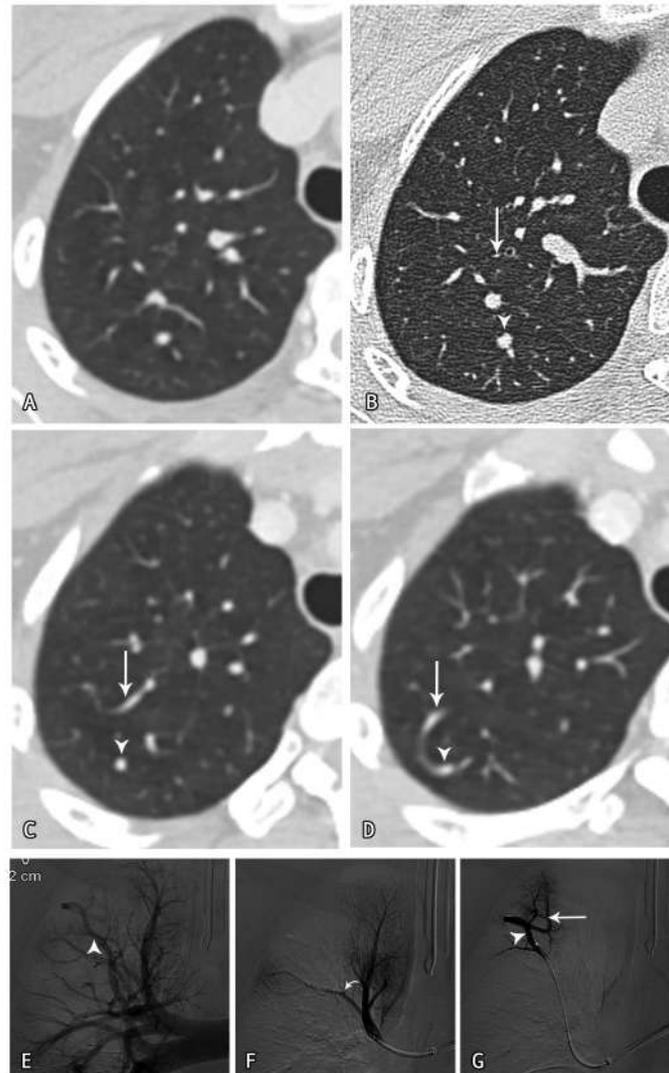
Pulmonary artery-to-pulmonary artery anastomosis in the right upper lobe. CT in lung window (A) and HRCT (B) at a similar level of the right upper lobe showing size disparity in the subsegmental pulmonary arteries in the right upper lobe. The thrombosed artery (arrow) is smaller than the accompanying bronchus while the patent one is dilated (arrowhead). More peripheral (C, D) the distal part of the thrombosed artery (arrow) is receiving supply from the adjacent dilated pulmonary artery (arrowhead). Right pulmonary (E) and selective angiograms of 2 branches of the right upper lobar artery (F, G) showing that the patent pulmonary artery (arrow head) has anastomosed with the distal part of the thrombosed one (arrow) and is supplying the lung parenchyma distal to the thrombosis (curved arrow)
